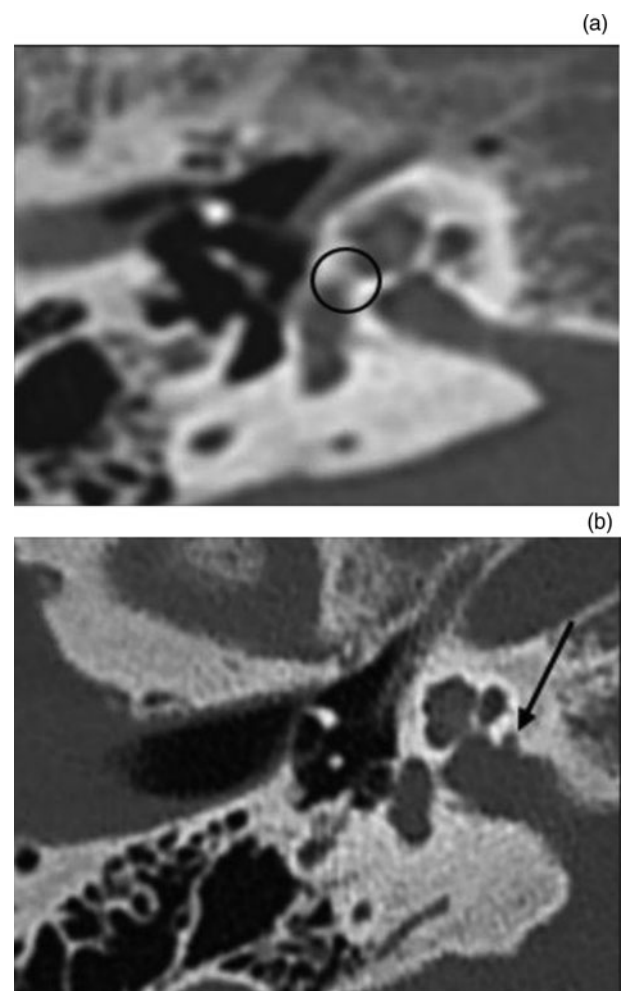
High-resolution computed tomography scan sections of the right temporal bone in the axial plane at the level of the oval window. (a) Shows the presence of endosteal extension of the ante fenestral focus of the disease (black circle). (b) Shows the presence of an internal auditory meatus diverticulum, the so-called 'nipple sign' (black arrow)
